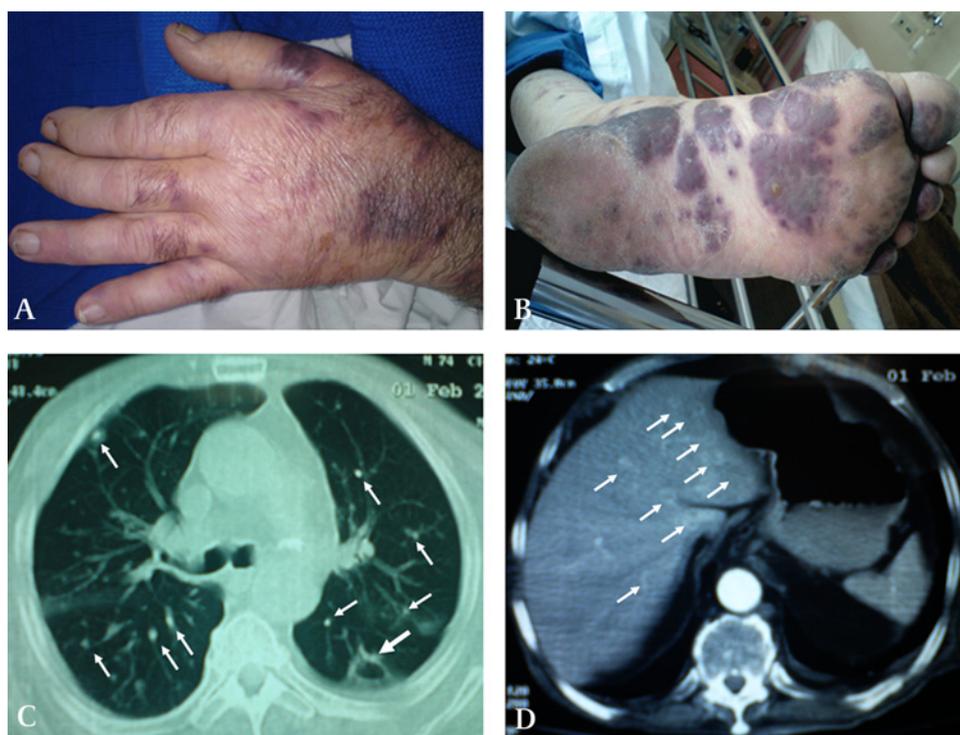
Papules and nodules on hands (A) and soles (B). (C) Chest CT scan showing multiple bilateral solid pulmonary nodules with peribronchovascular distribution and a cavitating nodule in the left lower lobe. (D) Abdominal CT scan showing multiple hepatic ring-enhancing lesions.
